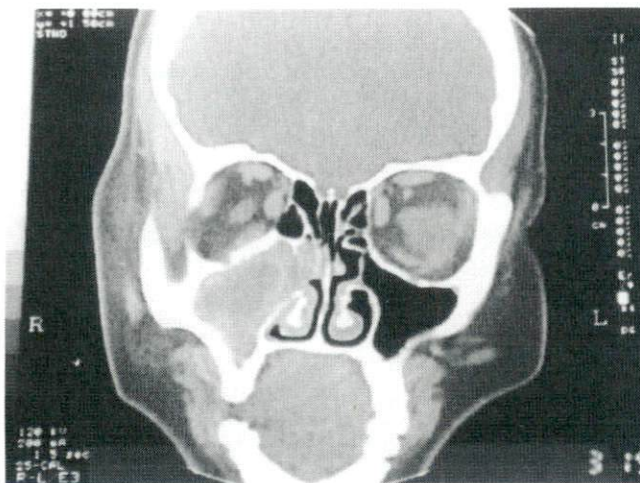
Computed tomography scan of the plasmacytoma in the maxillary and ethmoid areas.
